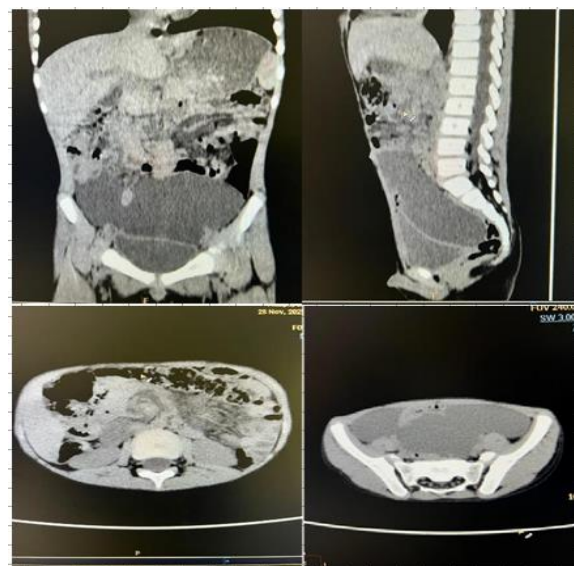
CT scan abdomen reveals Large cystic abdominal lesion demonstrating multiple septae. It is involving the retroperitoneal regions of the lower abdomen and pelvic region It shows homogenous density with soft tissue density (mean 40 HU).
